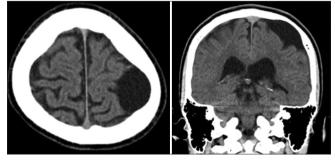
Computed tomography on admission, showing a hypodense, cystic lesion with bone thinning in the right convexity.
